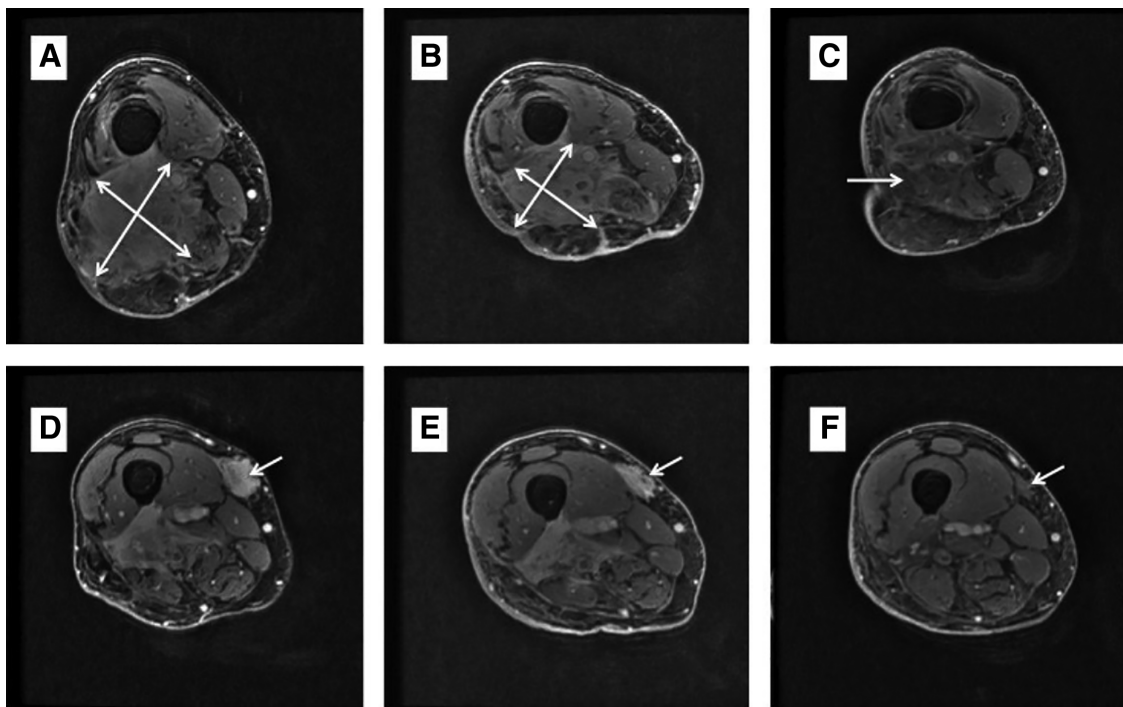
Patient 2 with pleomorphic undifferentiated sarcoma. Magnetic resonance imaging showing a large, heavily pretreated, recurrent, undifferentiated pleomorphic sarcoma in the right lateral thigh (A) and right medial thigh (D). Scan after five cycles of nivolumab (and radiation) showing small radiographic response in the right lateral thigh (B) and right medial thigh (D). (C): Scan after 11 cycles of nivolumab (and radiation) showing significant tumor shrinkage and complete resolution of pain and swelling in the right lateral thigh. (F): Excellent response to the lesion in the right medial thigh with diminished enhancement. Overall, the findings are suggestive of a near-complete response.
